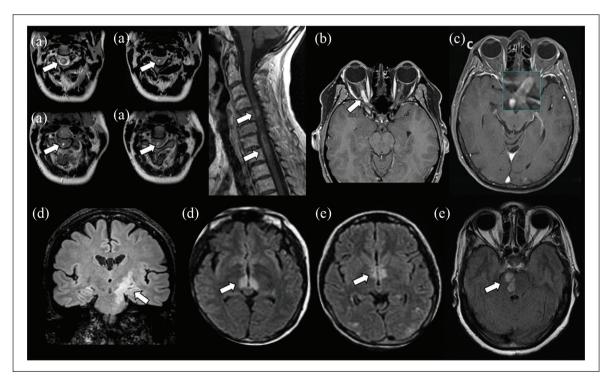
Asymptomatic MRI brain and spinal cord lesions during the relapse-free period:
